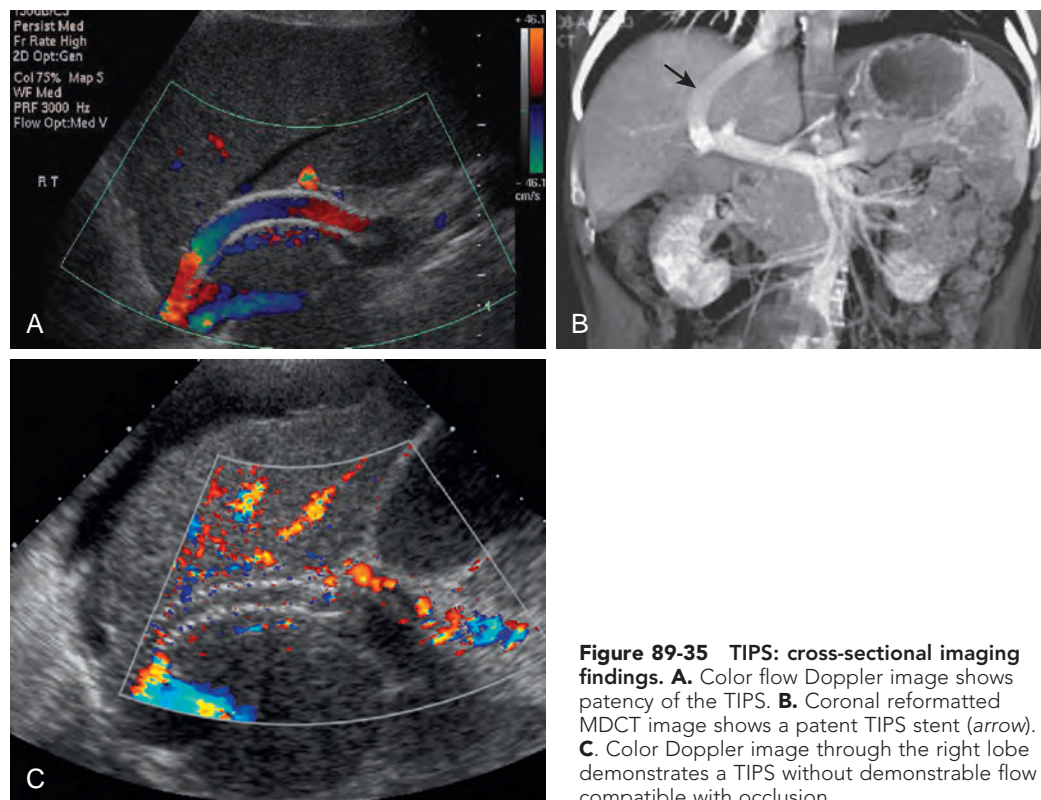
TIPS: cross-sectional imaging findings. A. Color flow Doppler image shows patency of the TIPS. B. Coronal reformatted MDCT image shows a patent TIPS stent (arrow). C. Color Doppler image through the right lobe demonstrates a TIPS without demonstrable flow compatible with occlusion.
